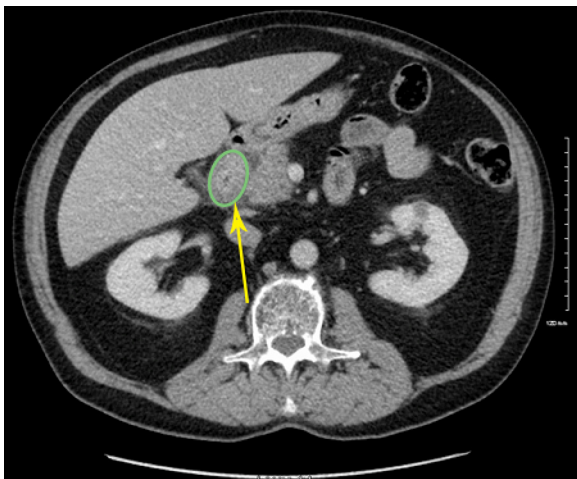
CT scan from 2 years prior demonstrating duodenitis (green circle) and periduodenal inflammatory change (yellow arrow).
